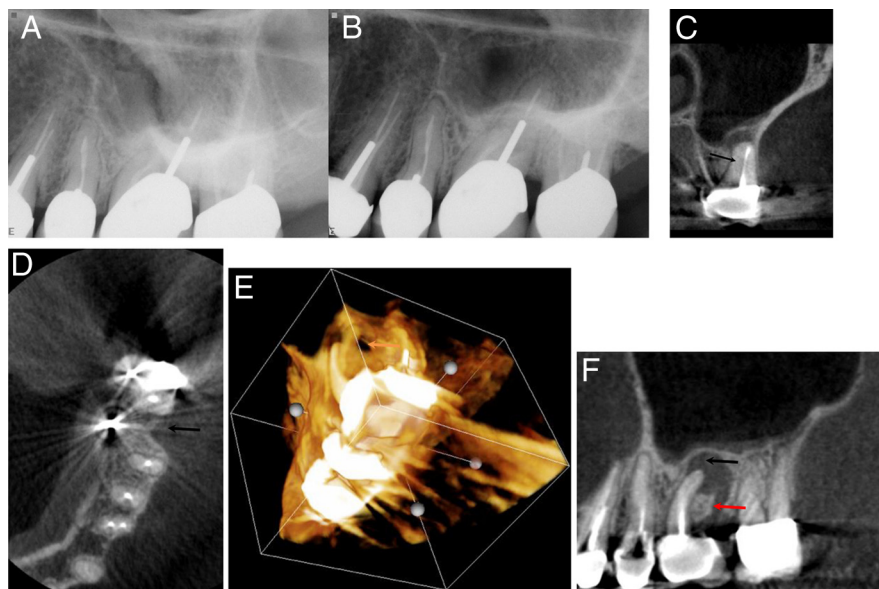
Case 3: this case represents tooth #14. (A and B) Periapical radiographs of tooth #14 mesial and distal angles, respectively. (C) A coronal view of the mesiobuccal root showing a missed mesiobuccal canal (*arrow*). (D) An axial view showing a previous distobuccal root amputation site (*arrow*) that was not obvious on the periapical radiographs. (E) A 3D reconstruction showing a crestal bony defect. (F) A sagittal CBCT view showing the crestal defect (*red arrow*) communicating with the periapical lesion (*black arrow*) and elevating the floor of the maxillary sinus with no evidence of sinus perforation.
